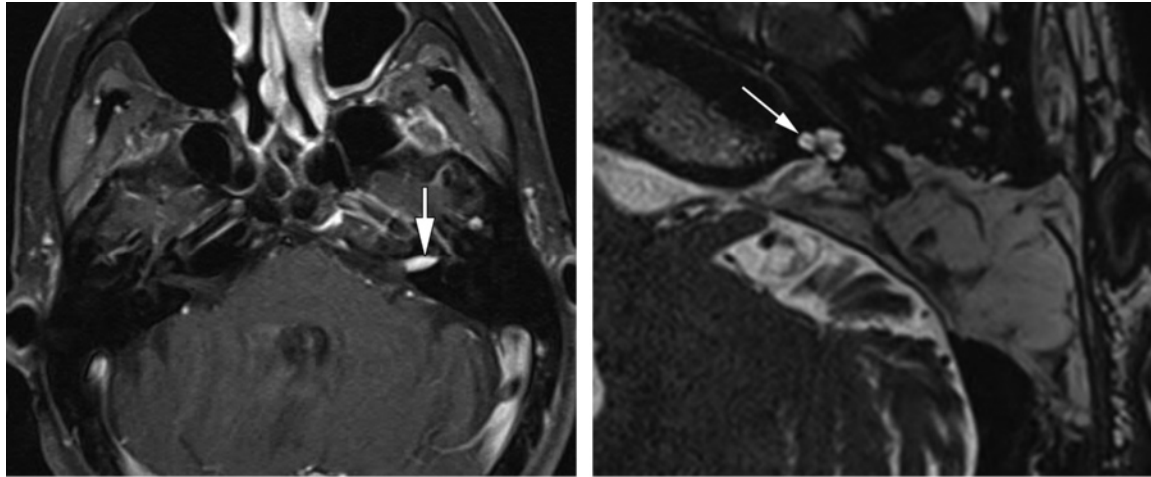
Translabyrinthine approach. (a) Axial fat-saturated T1-weighted MR image obtained prior to translabyrinthine resection shows a left intracanalicular schwannoma (arrow). A translabyrinthine approach was chosen because the patient had no useful hearing. (b) Axial 3D T2-weighted SPACE image obtained following left translabyrinthine resection shows the typical placement of a fat graft, which usually has a triangular shape and can undergo atrophy over time. The cochlea is intact (arrow).
